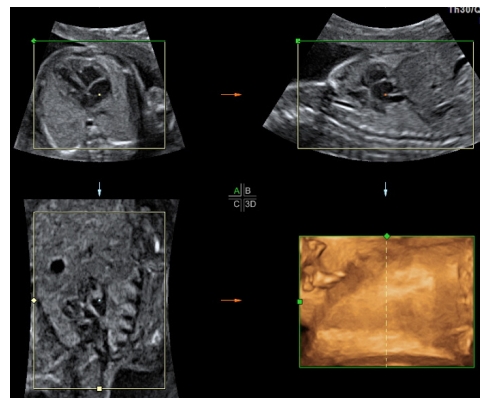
Initial multiplanar view of a 3-D sonographic volume of the fetal chest.
